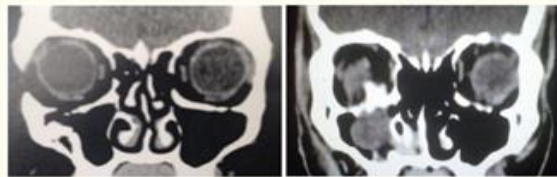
Computed tomography showing the reduction of the left orbital floor fracture corresponding to the case of figure 1 and 2.
